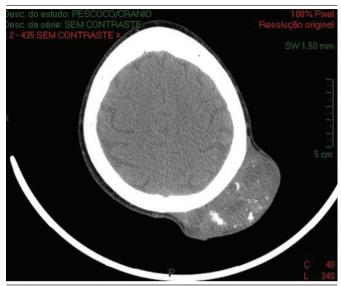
Computed tomography, axial view
